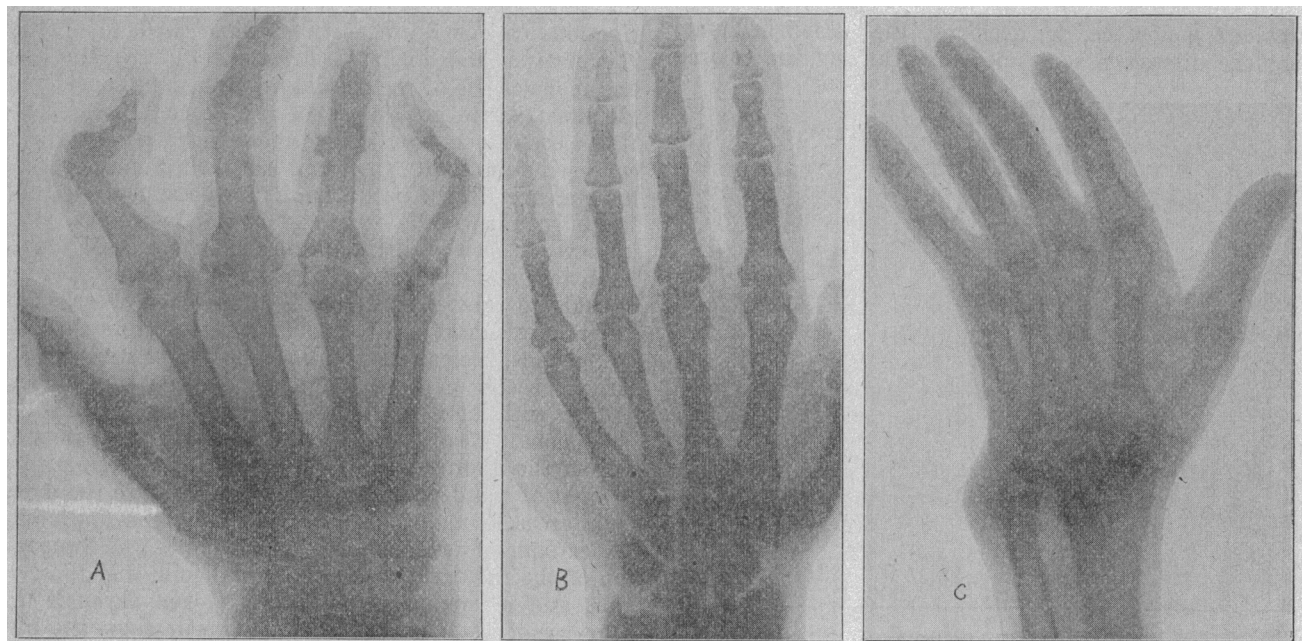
Radiograph of (A) gouty, (B) normal and (C) arthritis deformans hands.
